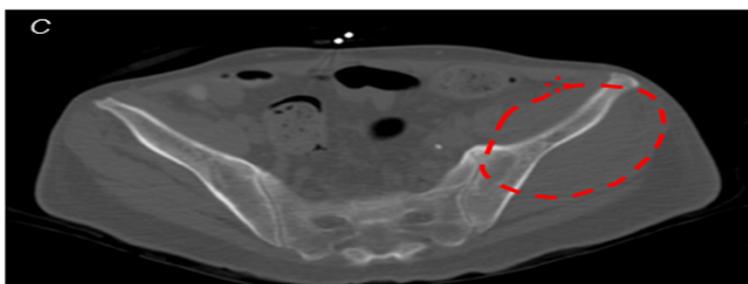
Clinical and radiographic appearance of chloroma. Chloroma in the oral cavity (A) and in the vulva (B). Chloroma in the left hemipelvis on (C) axial computed tomography imaging (dashed line) and (D) positron emission tomography.
